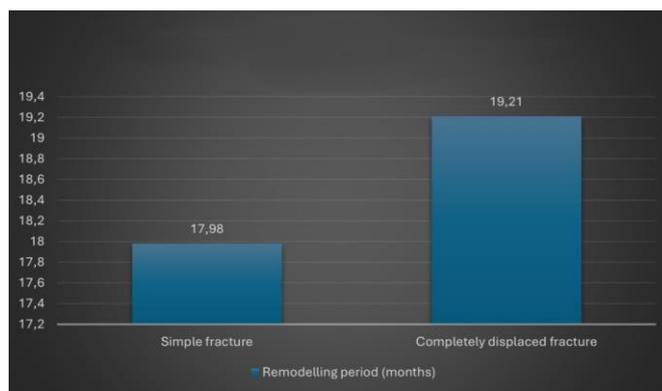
Mean remodeling period according to fracture type. Values represent mean time in months; no comparative statistical analysis was performed. Remodeling time indicates the time to radiographic documentation of complete remodeling.
